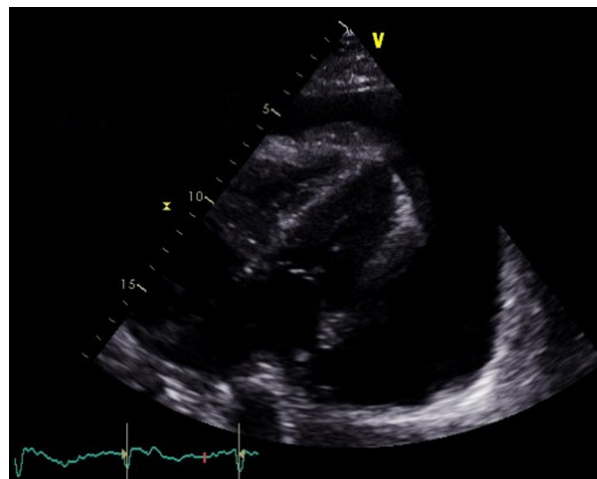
Trans-thoracic echocardiography exhibiting a large amount of anechoic pericardial fluid.
